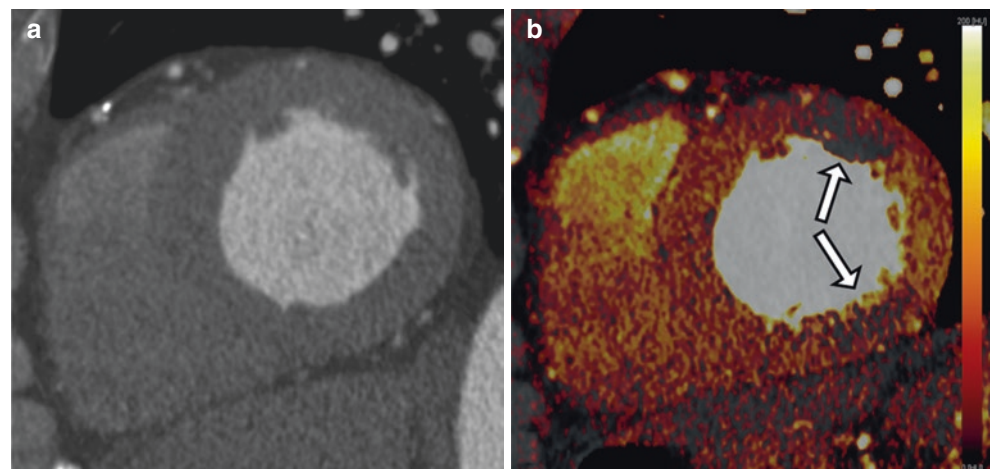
Dual-energy CT myocardial iodine maps. This figure shows a short-axis MPR image of the heart (a) where the myocardium appears normal. Post-processing of the dual-energy CT dataset allowed the generation of an iodine map of the myocardium (b) which helped detect areas of subtle hypoperfusion (*arrows*)
